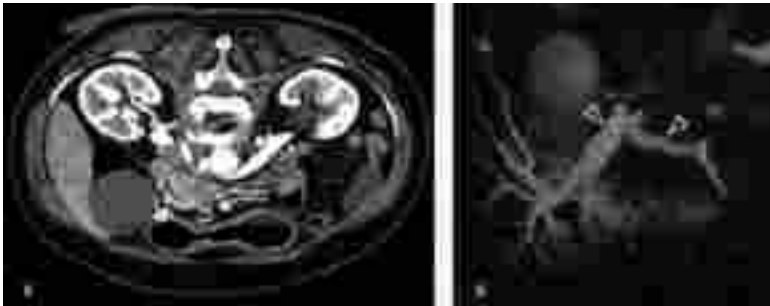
MRI of the pancreas
